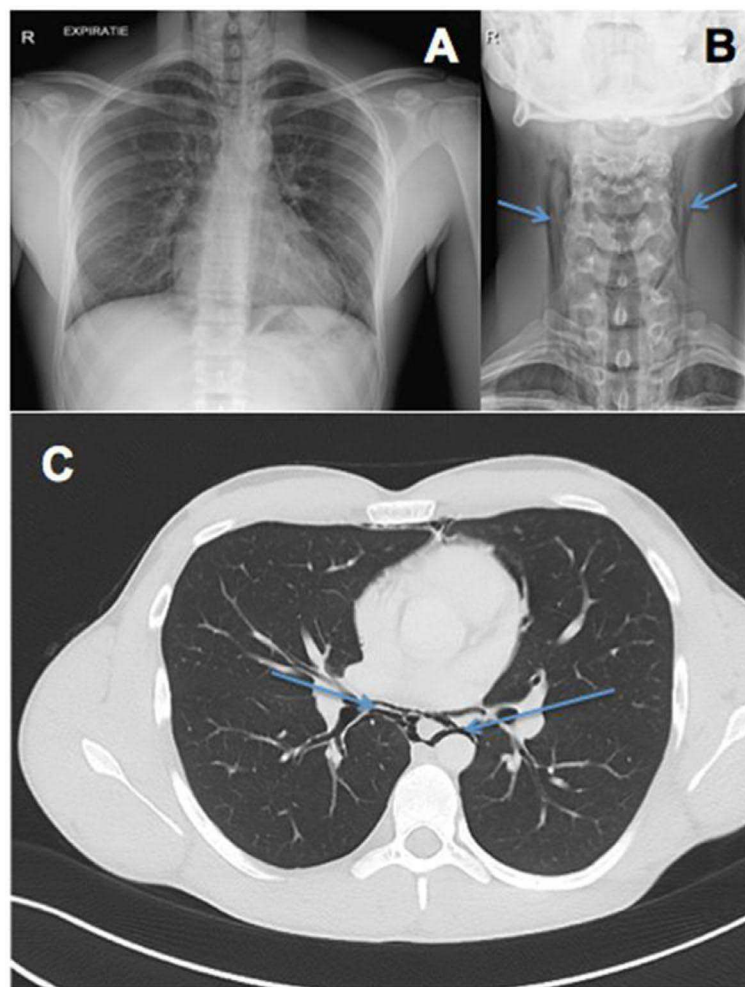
Chest X-ray showing a pneumomediastinum (A), subcutaneous emphysema (B) and chest CT scan showing air dissection along the peribronchovascular sheaths (Macklin effect, C).
